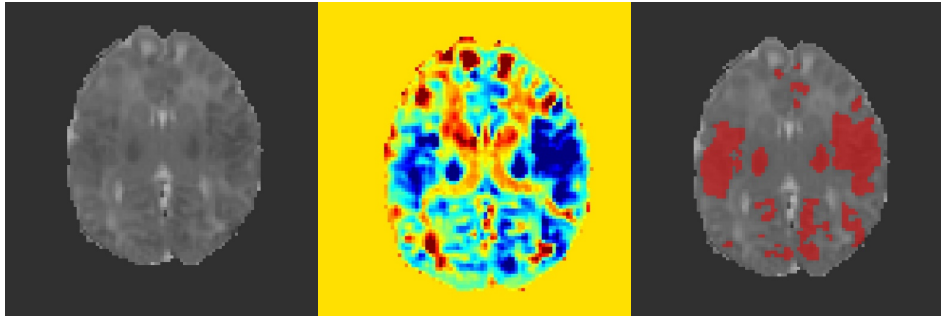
Example MRI maps from the BONBID-HIE dataset: ADC maps, Z-scored ADC maps (Z_{ADC}), and binary lesion masks (LABEL) for HIE lesion detection.
